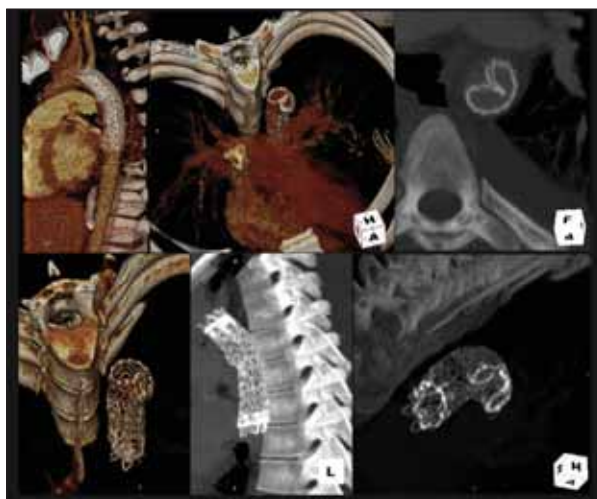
A 43-year-old man sustained blunt trauma to the descending thoracic aorta during a high-speed motor vehicle crash, which resulted in thoracic aortic disruption. He subsequently underwent TEVAR. The 3D and maximum-intensity projection images from 3-month follow-up CTA show collapse and infolding of the stent graft.
